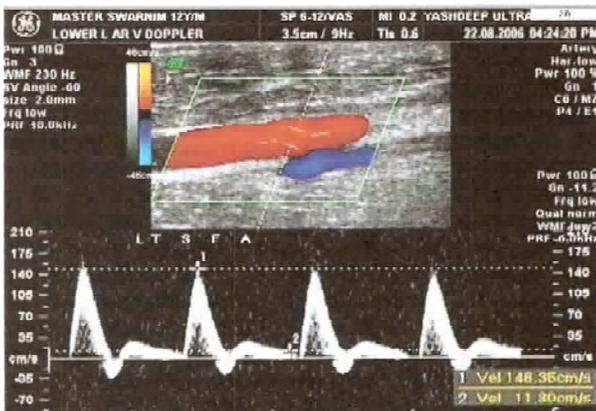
No. -3 Colour Doppler Study
